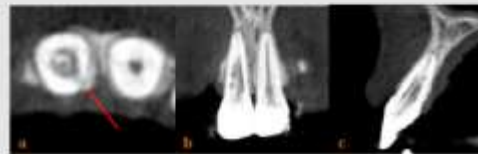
(a,b,c): CBCT view of the lesion. The entry point (2a) is located on the mesioapical surface (red arrow).
